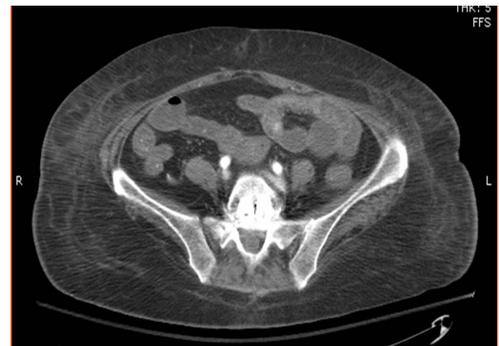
CT scan of the abdomen showed diffuse thickening of small bowel loops.
